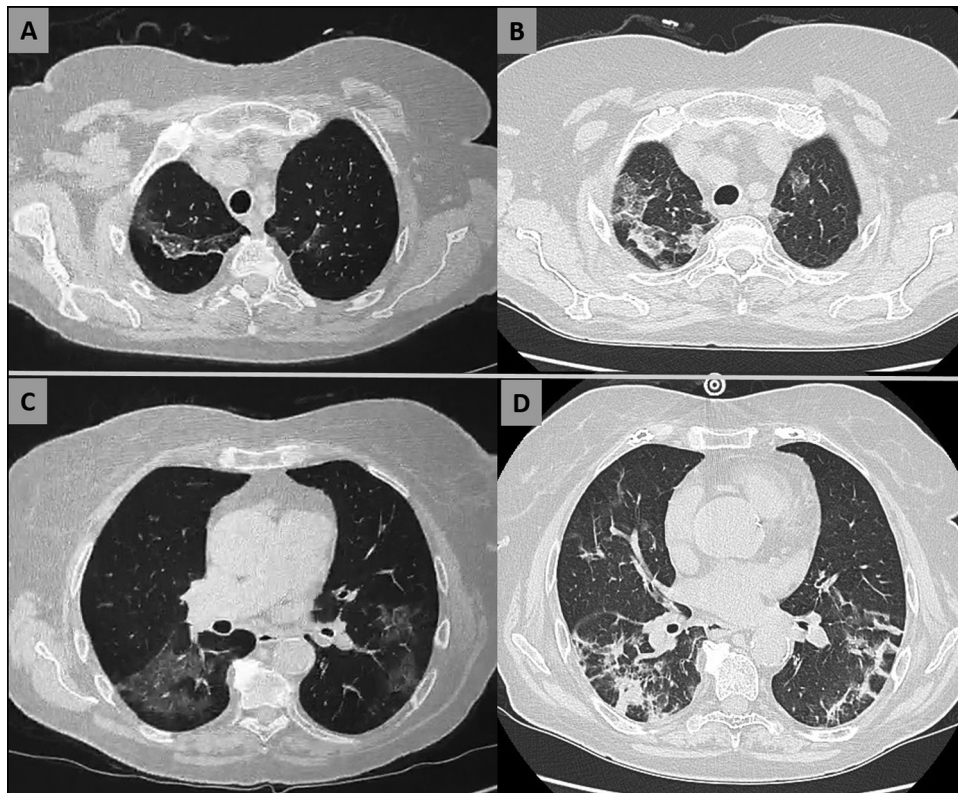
Axial non-contrast CT scans of the upper chest in the lung in an 82-year-old woman with COVID-19 pneumonia.
